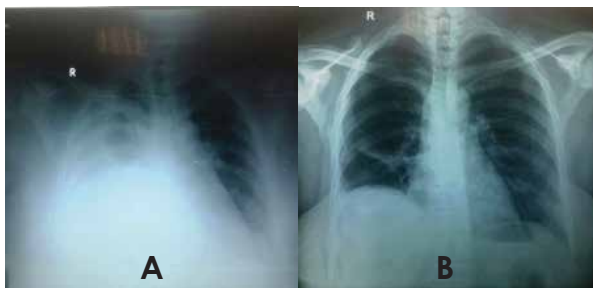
Chest X-ray 4th postoperative Day (after removal of Nephrostomy) showing right hydrothorax, Figure B: Chest X-ray on 10th postoperative day showing no residual intrapleural collection.
